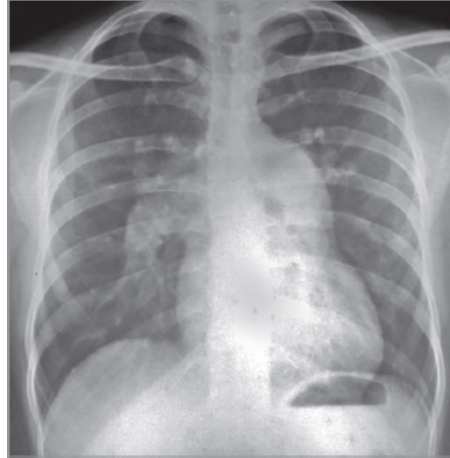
Chest X-ray PA view showing mild cardiomegaly, prominent pulmonary artery, pulmonary plethora, prominent right atrium. Suggestive of atrial septal defect—jug handle appearance.
